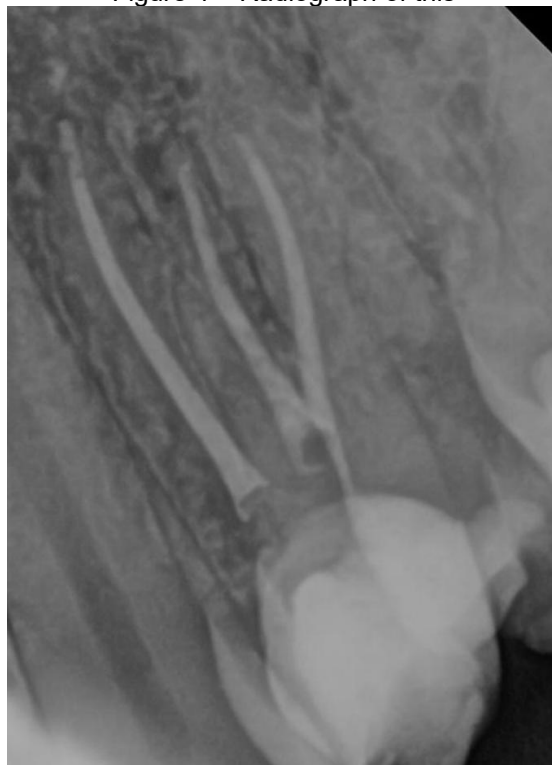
Radiograph of this
